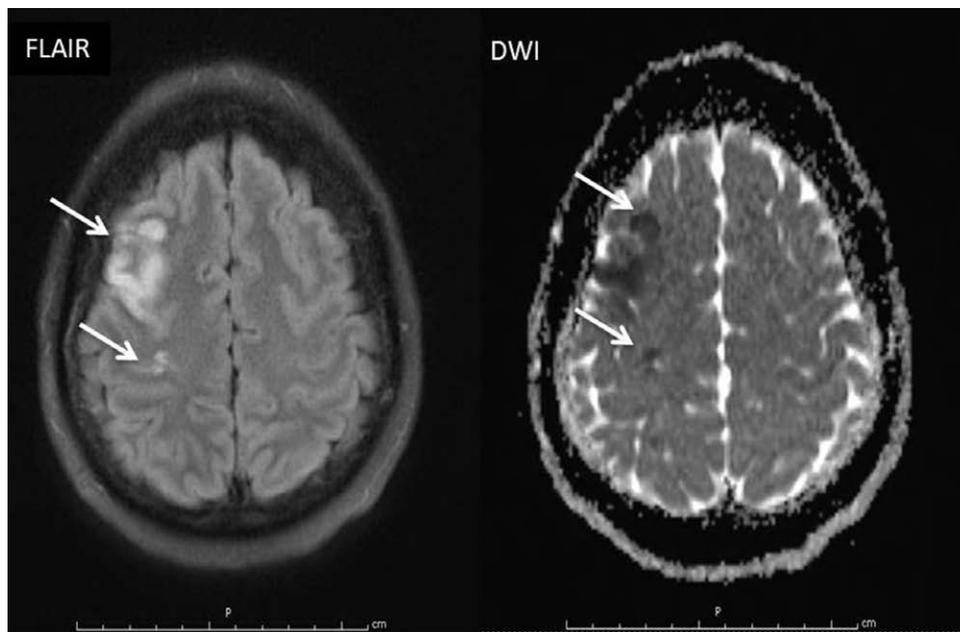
MRI brain: FLAIR image and DWI demonstrate ischemia of right frontal and parietal lobes (arrows). DWI, diffusion weighted image.
